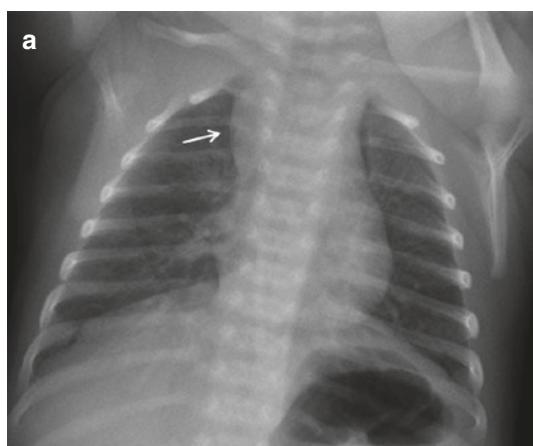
(a) PA chest radiograph of a 3-week-old girl with history of cyanosis with coughing spells. There is a well-defined soft-tissue density in the right upper mediastinum with no associated mass effect (arrow). (b) US
